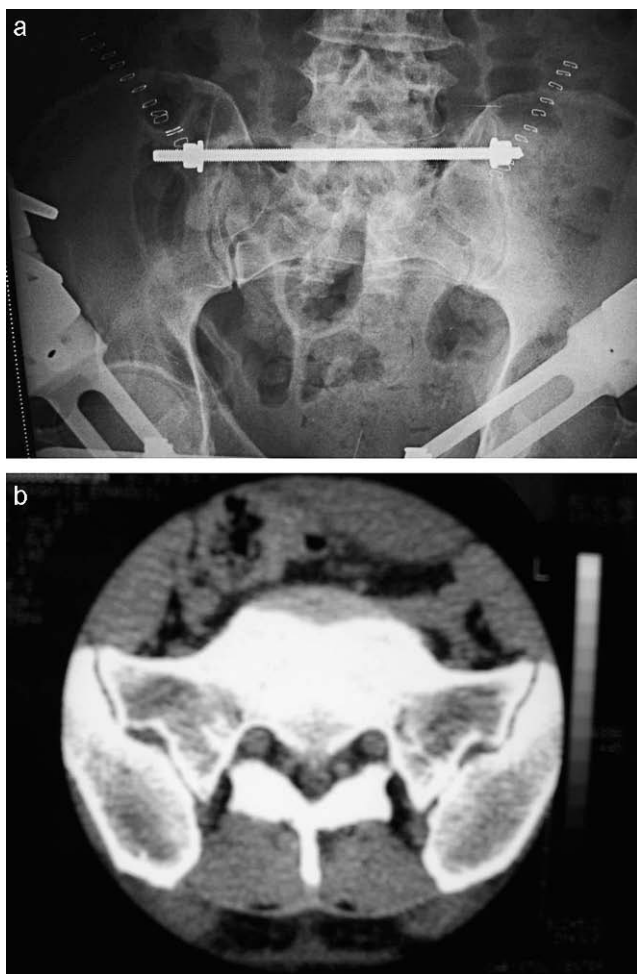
a) Internal fixation of the posterior pelvic injury using transiliac bar. b) CT of the pelvis at S1, 5 years before the accident.
